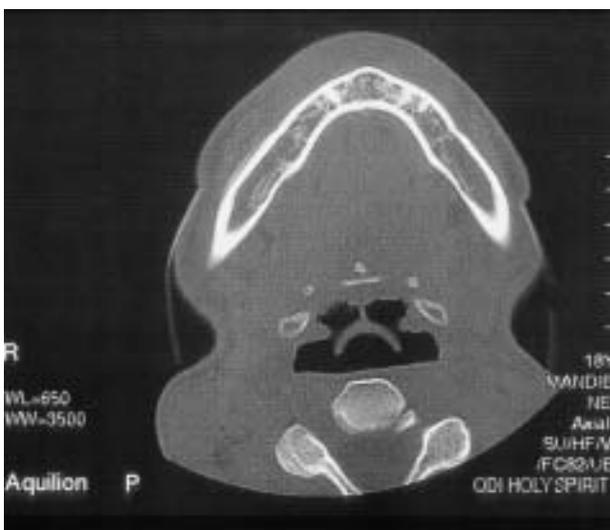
CT scan showing possible periostitis ossificans.
